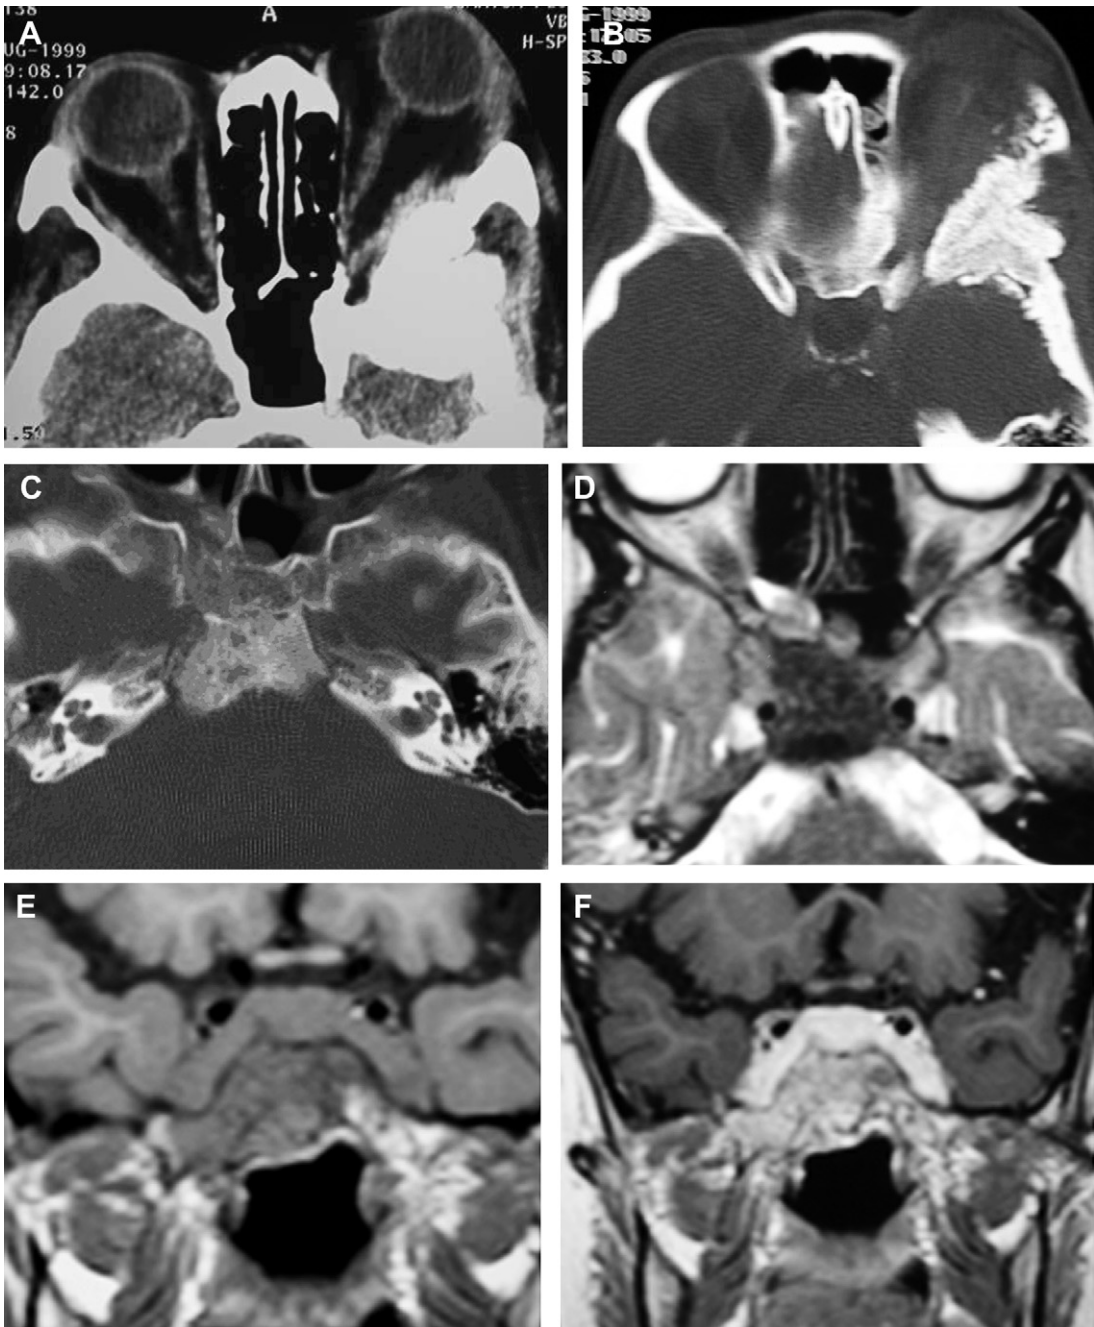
Axial CT images on soft tissue (A) and in a bone window (B) show an expansile sclerotic lesion in the left sphenoid triangle and lateral orbital wall with an aggressive sunburst pattern of periosteal reaction leading to proptosis (osteogenic osteosarcoma). (C) Axial CT image in a bone window in another patient shows a permeative lesion involving the clivus that is predominantly sclerotic but has small ill-defined lytic areas. Axial T2-weighted image (D) and coronal precontrast (E) and postcontrast (F) T1-weighted images in the same patient show that the lesion is markedly hypointense on T2-weighted imaging, is of intermediate signal intensity on T1-weighted imaging, and enhances vividly after gadolinium administration. The lesion bulges inferiorly in the left nasopharyngeal roof (osteosarcoma secondary to prior irradiation of a posterior fossa medulloblastoma).
